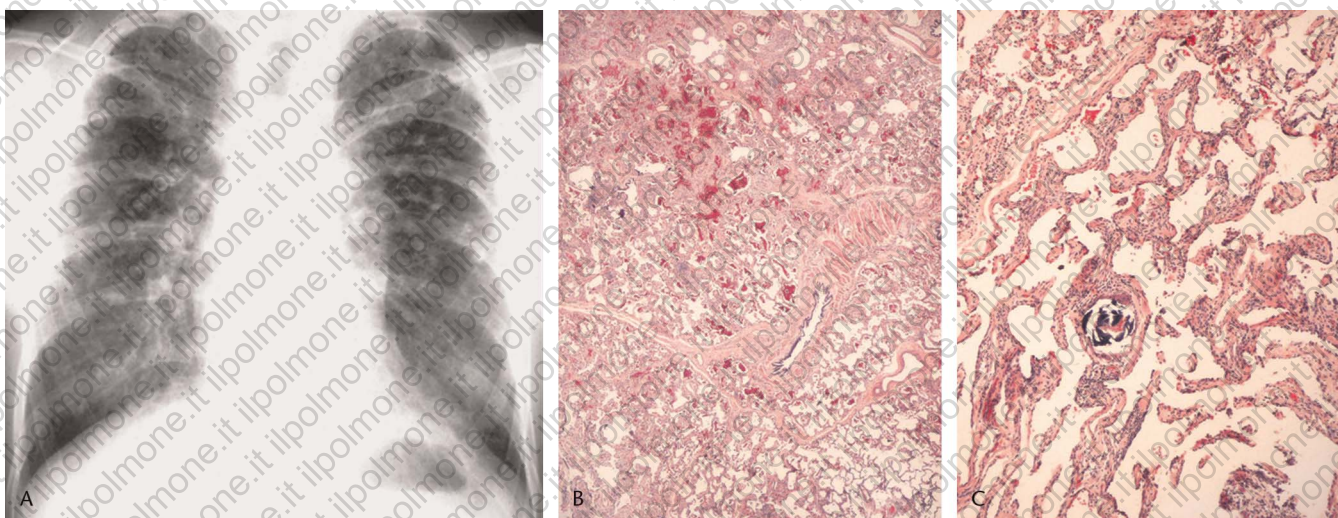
Chronic HP in a child with long term pigeon exposure (case no. 5). A, Chest radiograph shows reticular pattern in the middle and upper lung zones. B, Low power view shows homogeneous linear fibrosis in an NSIP-like pattern. C, Another area demonstrating both linear fibrosis and a Schaumann body with surrounding giant cells. *a+*
